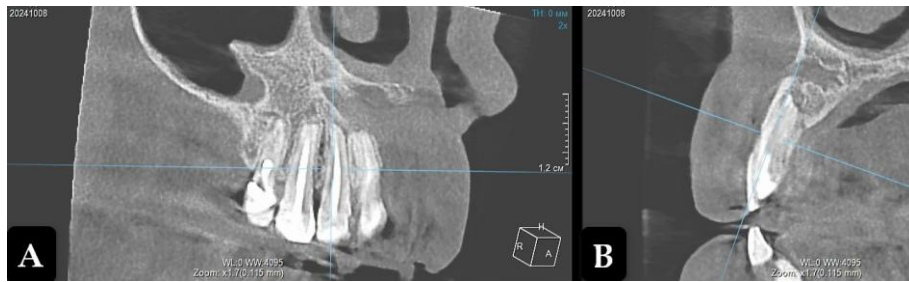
Cone-beam computed tomography. Residual bone cavity 2 year after enucleation of radicular cyst (projection of tooth 12). A: Frontal projection; B: Sagittal projection.
